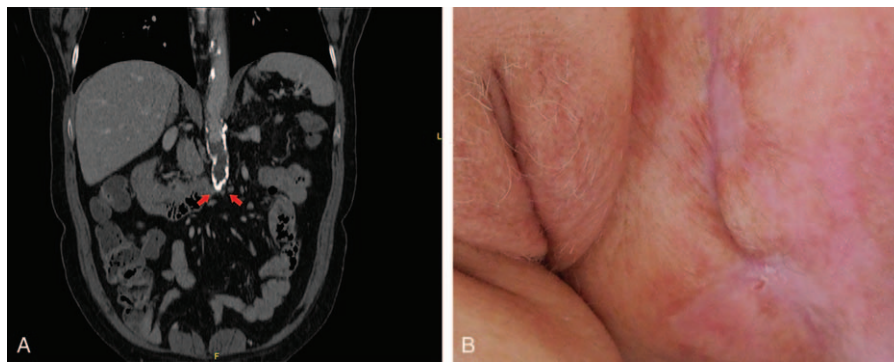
(A) CT scan showing total aortic occlusion below the renal arteries. (B) Healing of the ulcers after axillofemoral bypass surgery. CT=computed tomography.
